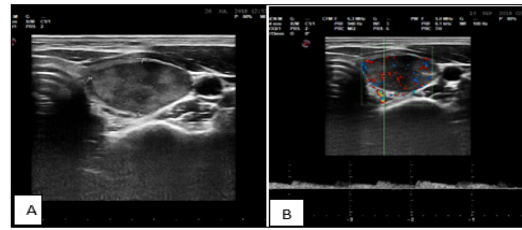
ATA Thyroid Nodule Sonographic Patterns Intermediate Suspicious Lesion. Pathological diagnosis Follicular lesion of unknown significance – Bethesda – III.
